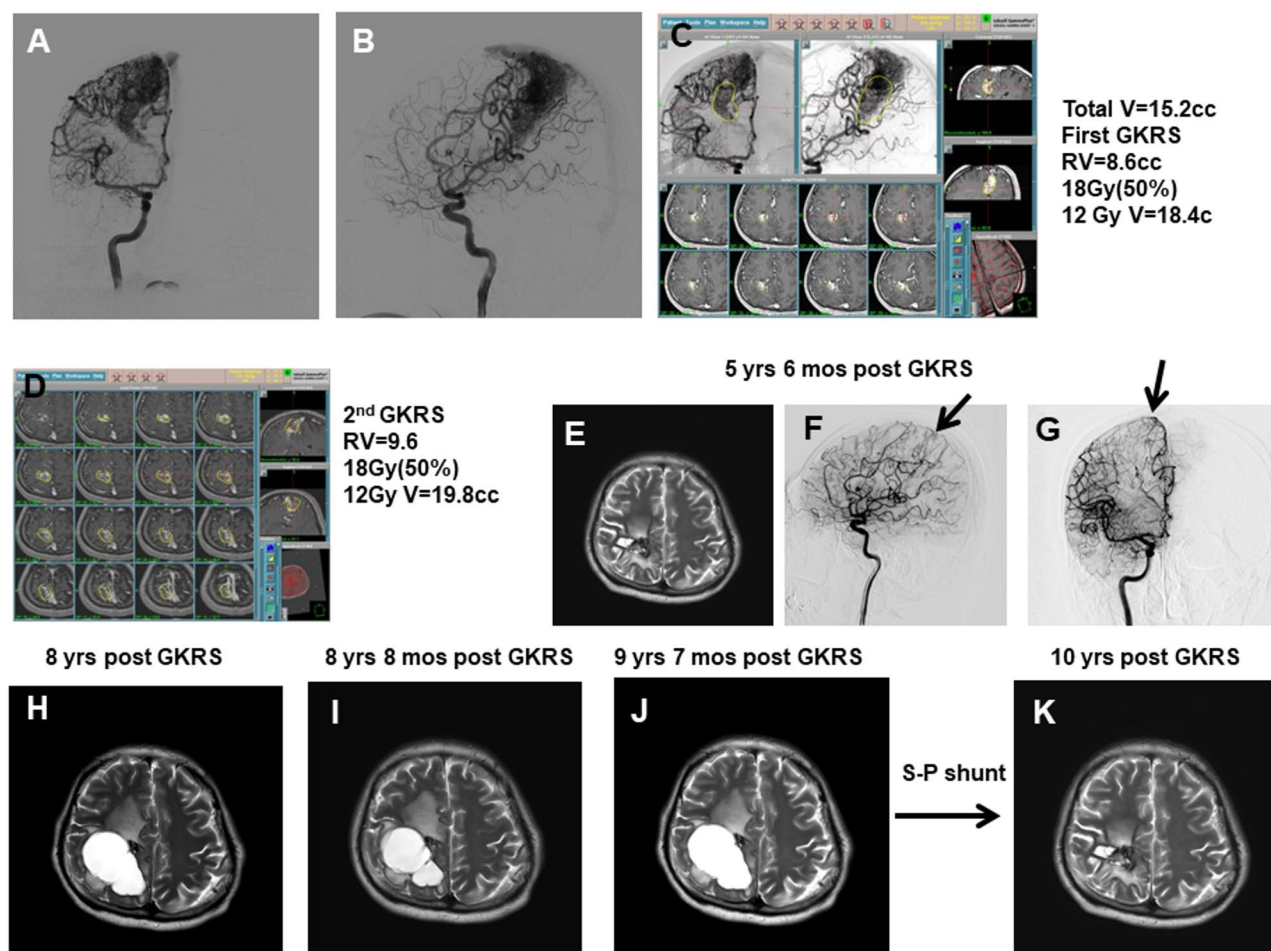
A 28-year-old male presented with focal seizure and diagnosed as a huge AVM with volume of 15.2 cc. The treatment was separated into 2 stages under the guidance of AVM volume 15–20 cc in eloquent locations treated in two stages treatment. The post GKRS imaging showed the tiny residual nidus and cyst formation mandatory of s-p shunt with clinical symptoms of left leg clumsy movement. (A) Anteroposterior view of cerebral angiography showed an AVM located in the right parietal lobe, with arterial supply from the right anterior and middle cerebral arteries and venous drainage into the deep venous system and the superior sagittal sinus. (B) Lateral view of cerebral angiography showed an AVM in the right parietal lobe, supplied by the right anterior and middle cerebral arteries, with drainage into the deep venous system and the superior sagittal sinus. (C) Photograph showing dose planning for the first stage of Gamma Knife radiosurgery. Treatment parameters are displayed on the right side of the image. The yellow line represents the 50% isodose line. (D) Photograph showing dose planning for the second stage of Gamma Knife radiosurgery. Treatment parameters are shown on the right side of the image. The yellow line indicates the 50% isodose line. (E) A small cyst was detected at the targeted lesion on T2-weighted MRI, 5 years and 6 months after the first GKRS. However, no definite symptoms were noted at that time. (F) A small nidus, indicated by the arrowhead, was identified in the lateral view of cerebral angiography 5 years and 6 months after the first GKRS. (G) A small nidus, indicated by the arrowhead, was detected in the anteroposterior view of cerebral angiography 5 years and 6 months after the first GKRS. (H) A large cyst in the right parietal region was observed on T2-weighted MRI 5 years and 9 months after GKRS. Neurological examination revealed clumsiness in the left leg. (I) A large cyst in the right parietal region was noted on T2-weighted MRI 6 years and 3 months after GKRS. Neurological examination showed continued clumsiness in the left leg without further deterioration. (J) A large cyst in the right parietal region was detected on T2-weighted MRI 7 years and 3 months after Gamma Knife treatment. Neurological examination revealed worsening clumsiness in the left leg. A cyst-peritoneal shunt was scheduled at this time. (K) A small residual cyst was detected on T2-weighted MRI 10 months after the cyst-peritoneal shunt. Neurological examination showed improvement in left leg movement
